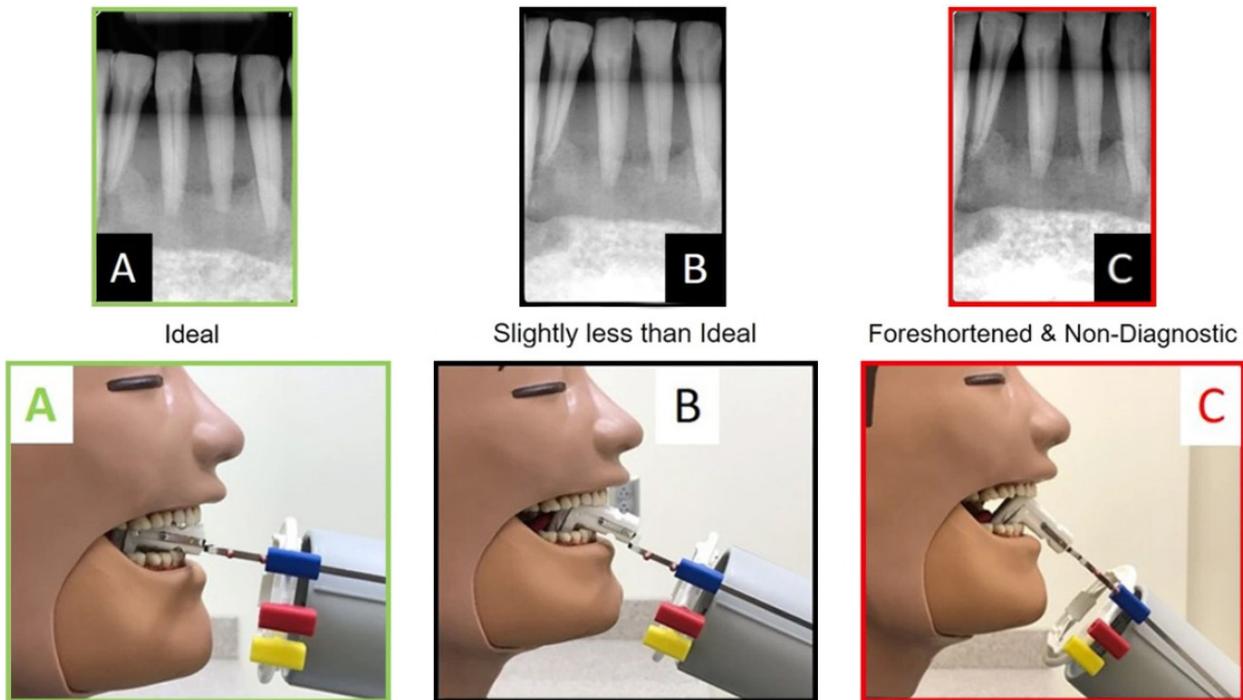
Mandibular anterior periapical setups and resultant images. The effects of different positions of the sensor holder can be drastic. (A) is ideal, (B) is slightly less than ideal, but still diagnostic, (C) is Non-Diagnostic as the crowns are off the image and the teeth are foreshortened.
